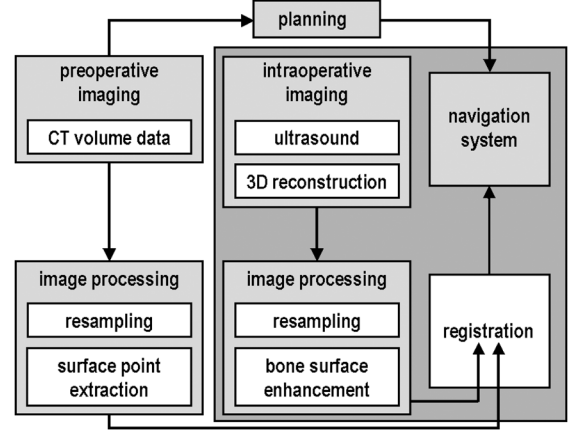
Concept of the integration of ultrasound into navigated surgery on the spine.
